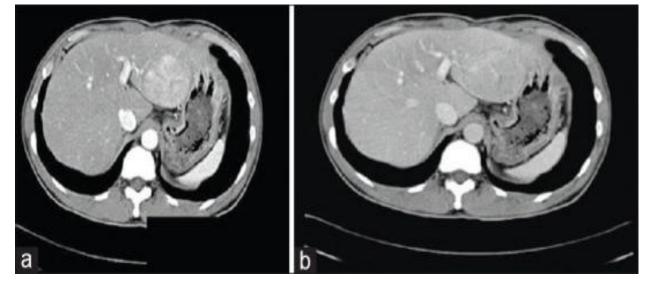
(a) Enhanced HCC lesion in the arterial phase of a CT scan (b) Early washout of contrast in the venous phase
